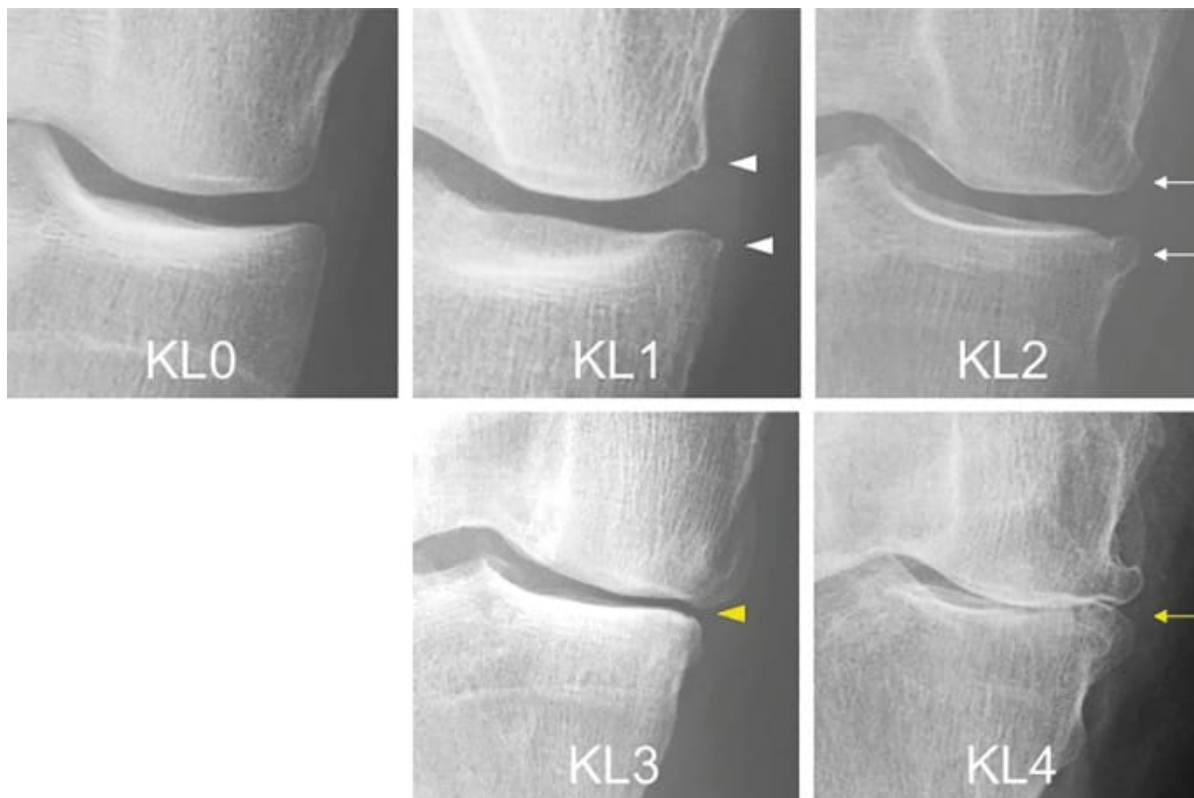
Osteoarthritis (OA) progression of the knee joint medial compartment assessed via KL grading. KL grade 4 shows the bone-to-bone end-stage OA (Adapted from Sekiya, I., Katano, H., Guermazi, A. et al. Association of AI-determined Kellgren–Lawrence grade with medial meniscus extrusion and cartilage thickness by AI-based 3D MRI analysis in early knee osteoarthritis. *Sci Rep* 13, 20093 (2023). <https://doi.org/10.1038/s41598-023-46953-9>, Creative Commons Attribution License CC-BY 4.0.)
